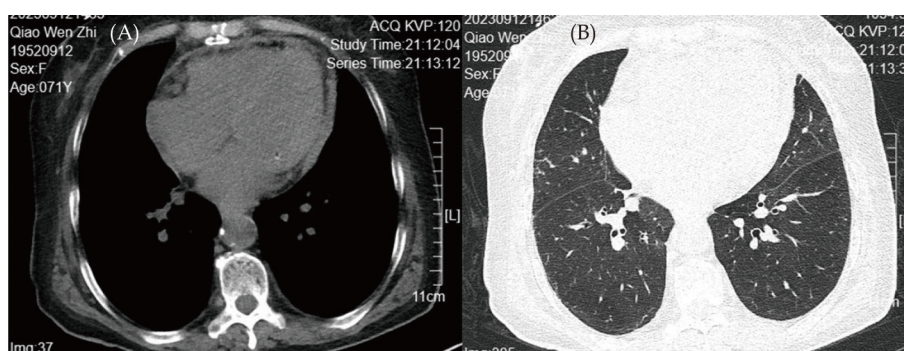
CT images. (A): Initial CT demonstrated thickening of the pericardium; (B): contrast-enhanced CT image.
